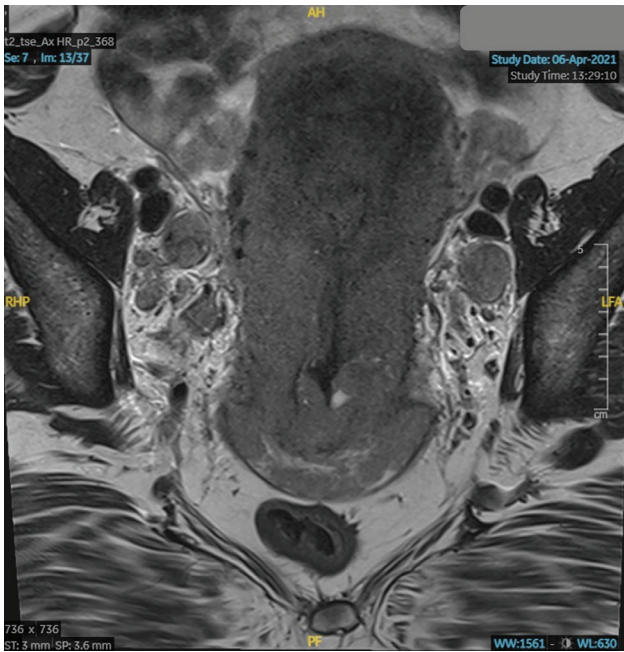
MRI showing the cervical mass (shown with black arrows) with lymphadenopathy (shown with white arrows).
